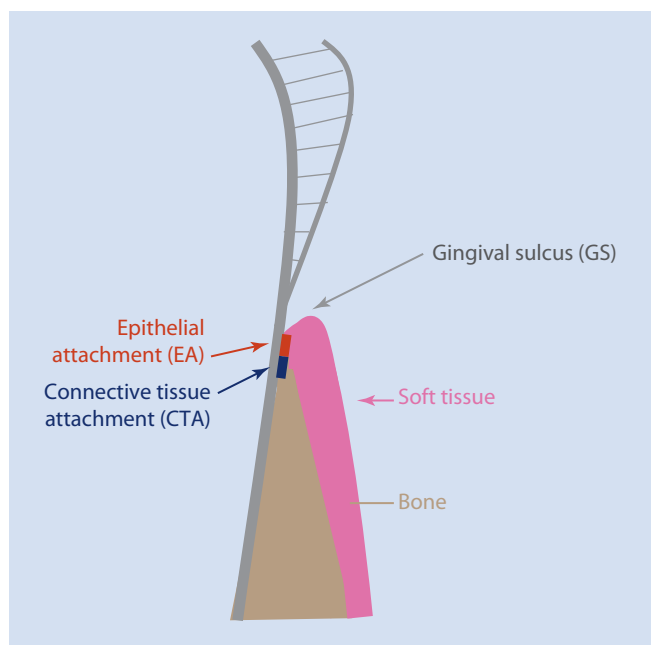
A graphic depiction of the dentogingival complex (DGC) and the biologic width (W). BW is composed of the epithelial attachment (EA) and the connective tissue attachment (CTA) and usually measured as a total of 2.0 mm. The DGC includes the gingival sulcus (GS) with a minimum depth of 1.0 mm
